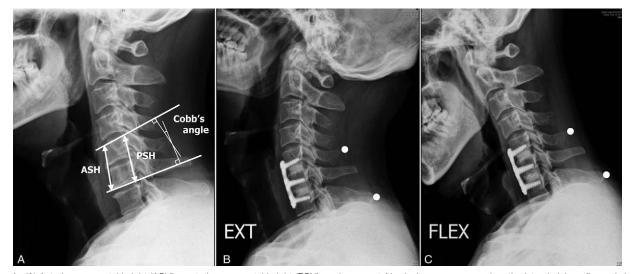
(A) Anterior segmental height (ASH), posterior segmental height (PSH), and segmental lordosis were measured on the lateral plain radiograph (neutral position). (B, C) Bone fusion was defined by a < 2-mm widening of the interspinous distance on the lateral flexion-extension plain radiograph.
